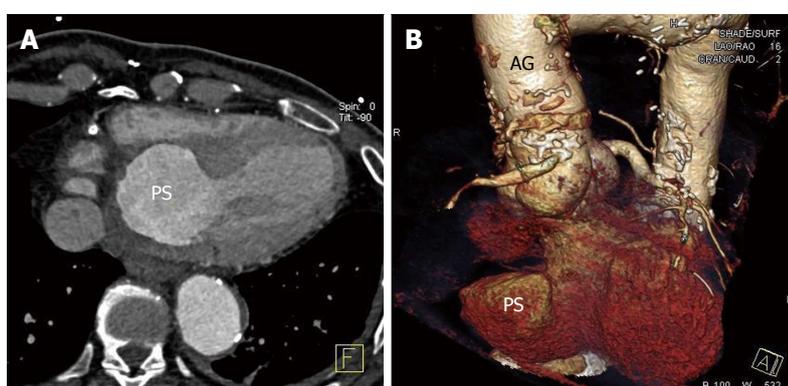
Cardiac computed tomographic angiography (A) and volume rendering (B): Left ventricle posterior wall pseudoaneurysm. PS: Pseudoaneurysm; AG: Aortic graft.
